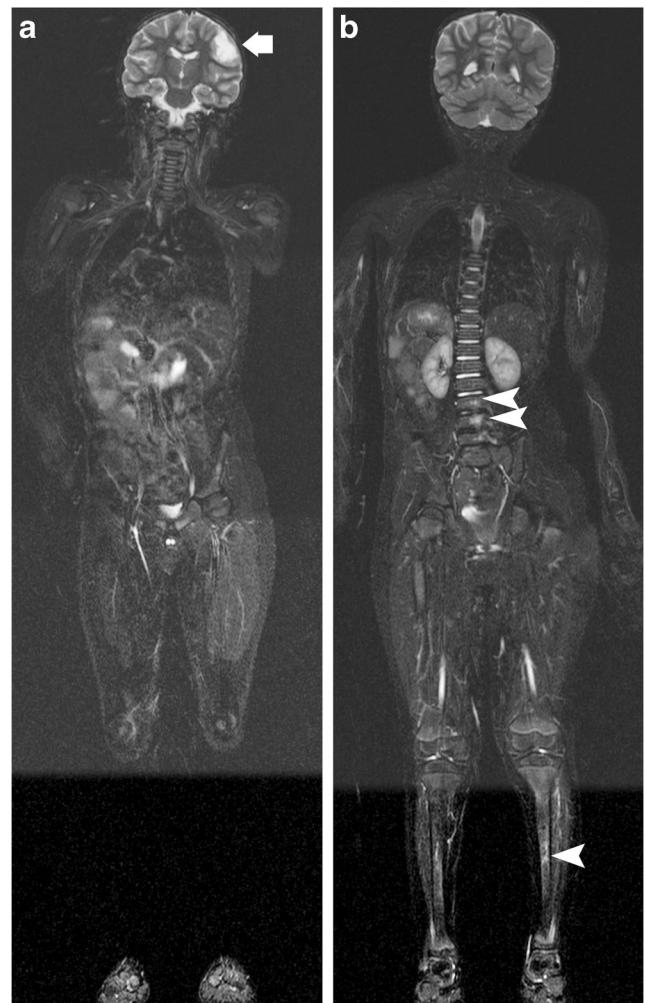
Hereditary retinoblastoma in a 4-year-old boy. a, b Whole-body MRI utilizing coronal short tau inversion recovery (STIR) sequence shows (a) increased signal in the left parietal lobe following treatment of a central nervous system metastasis (*arrow*), and (b) nonspecific bone marrow STIR hyperintensities in the lumbar vertebrae and left tibia (*arrowheads*)
